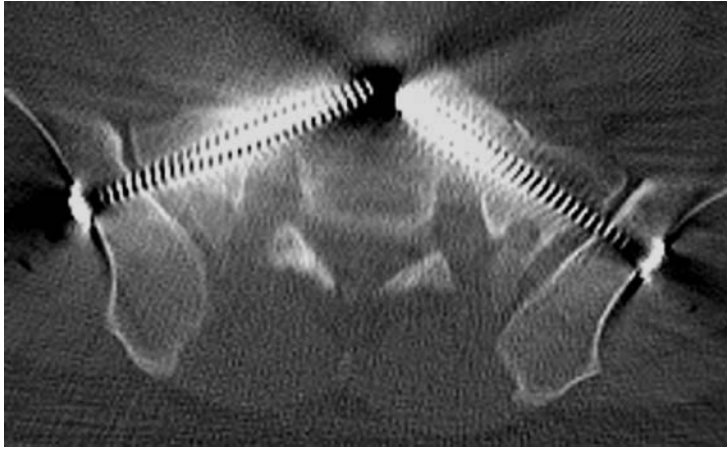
The postoperative pelvic CT axial image at the dysmorphic upper sacral segment demonstrates the oblique, narrow, and shorter screw pathways bilaterally.
